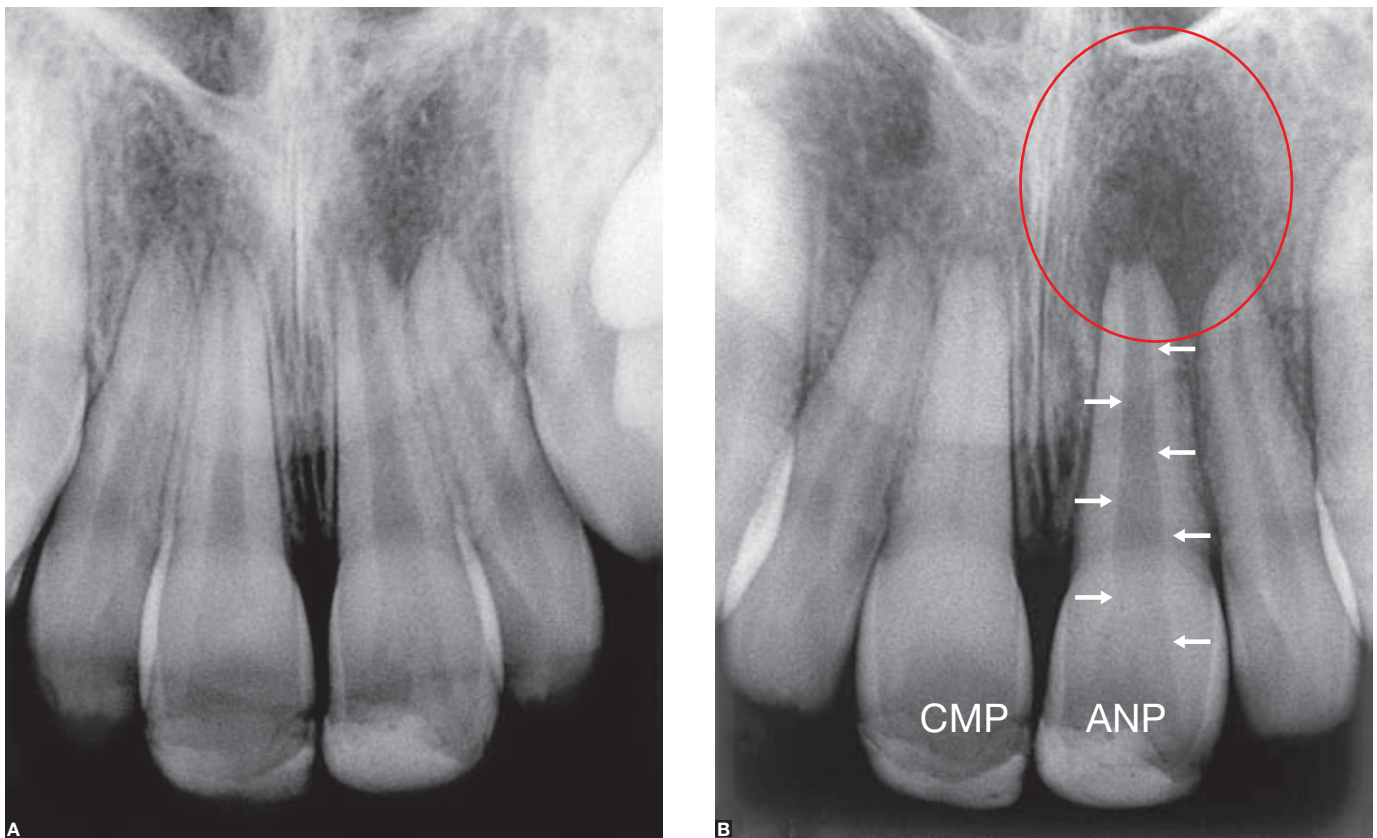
Central incisors had dental trauma according to patient's reports; no professional follow-up, as indicated by the crown lesion on radiograph obtained on an unknown date. The right central incisor progressed into calcific metamorphosis of the pulp (CMP) in some months, and radiograph shows practically no pulp margins and practically total obliteration of the chamber and root canal. Left central incisor had aseptic necrosis of the pulp (ANP), which progressed into chronic periapical lesion (circle), with preservation of well-defined pulp margins (arrows). The diagnosis was made using radiographs obtained for orthodontic planning as there were no symptoms (Source: Consolaro, Bernardini,⁸ 2007).
